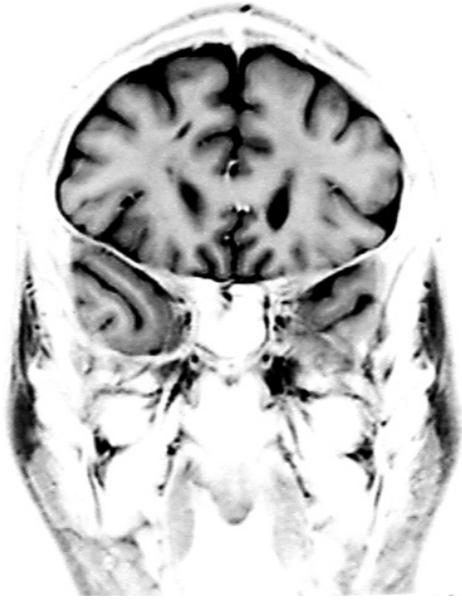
An inverted MRI scan (coronal section) of the brain through the anterior horn of the lateral ventricle. Observe the body and rostrum of the corpus callosum individual cerebral lobes, gyri and the septum pellucidum
